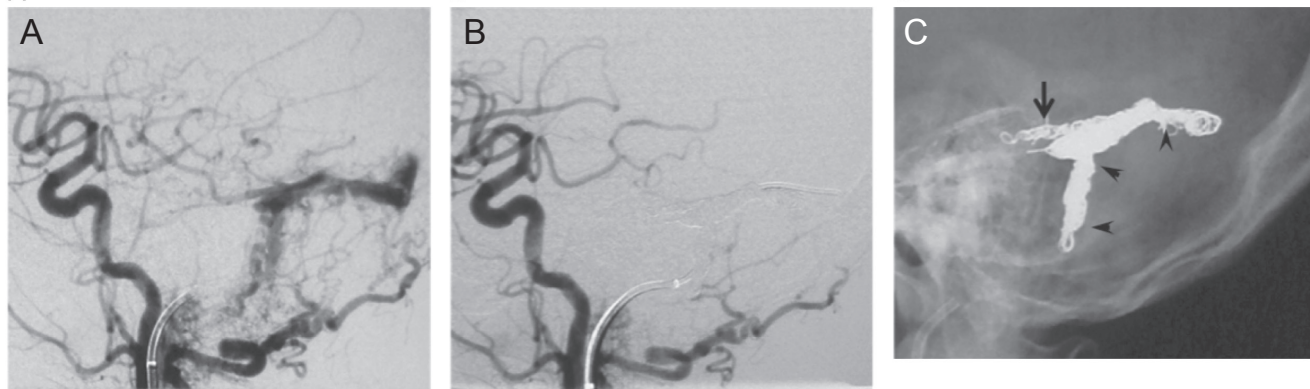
An 87-year-old woman with left transverse-sigmoid sinus dural AVF underwent transvenous embolization. A: Lateral view of left common carotid angiography showed transverse-sigmoid sinus dural AVF fed by meningeal branches of the left occipital carotid artery. The drainage routes was vein of Labbe or other cortical vein, B: Vein of Labbe was embolized with detachable coils. Subsequently sinus packing was performed using 13 CSCs and one fibered coil. The dural AVF was completely obliterated, C: Skull X-ray showing detachable coils (*arrow*) and CSCs (*arrowhead*). AVF: arteriovenous fistula, CSC: c-stopper coil.
